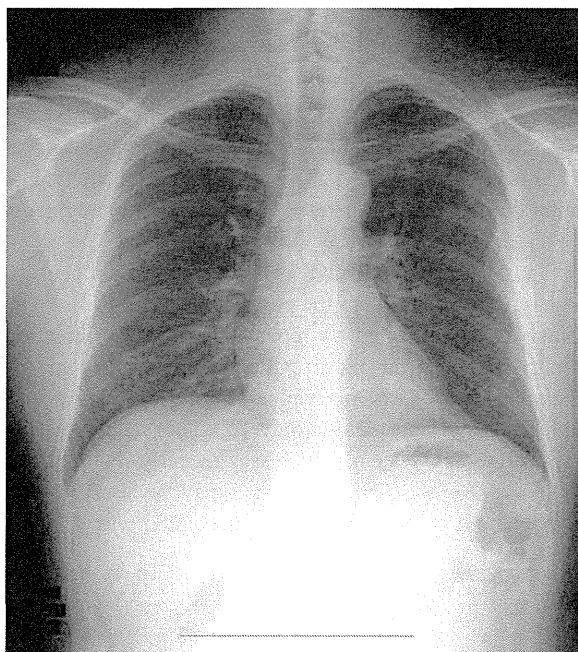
Chest radiograph showing localized enlargement of the left fifth rib.
